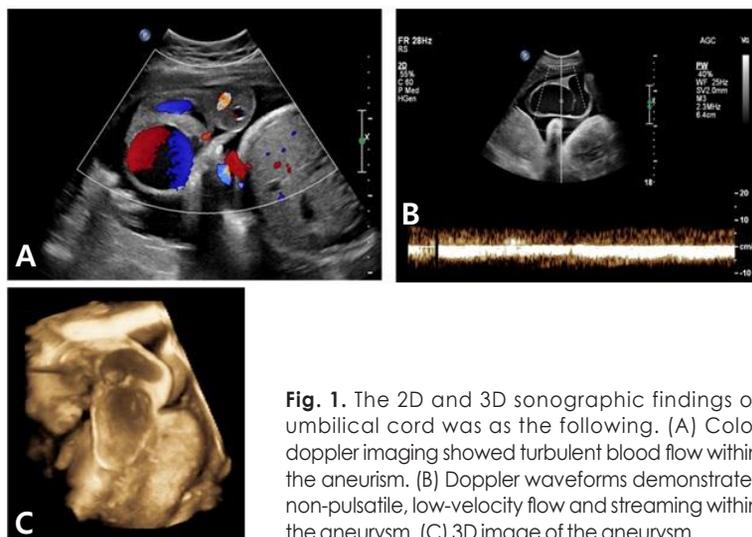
The 2D and 3D sonographic findings of umbilical cord was as the following. (A) Color doppler imaging showed turbulent blood flow within the aneurysm. (B) Doppler waveforms demonstrates non-pulsatile, low-velocity flow and streaming within the aneurysm. (C) 3D image of the aneurysm.
